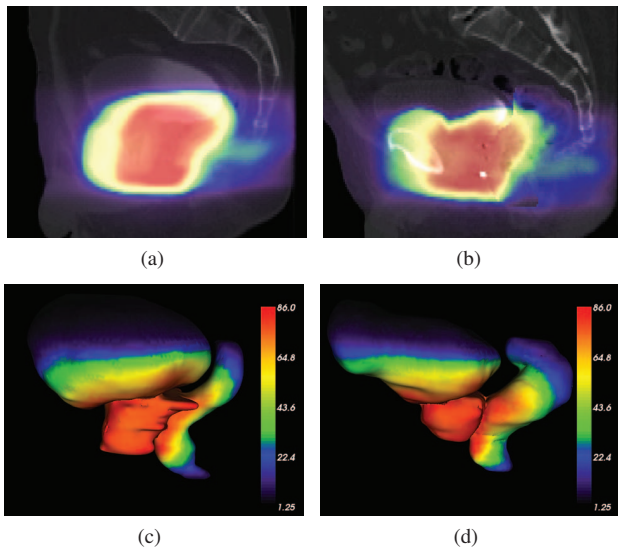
Individual's dose distribution computed during the radiotherapy planning overlaid on a) the individual's CT in the native space ; b) propagated, using a trilinear interpolation, towards the template coordinate system. c) 3D representation of prostate, bladder and rectum with the corresponding dose distribution in the individual's space and d) propagated to the template 3D structures.
